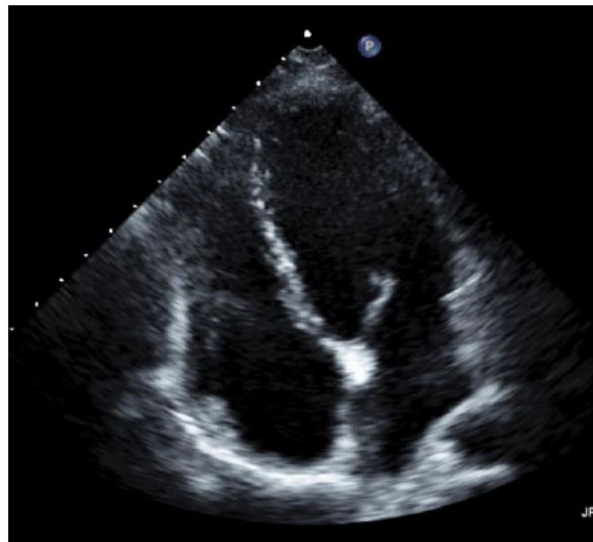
Transthoracic echocardiogram images of a normal diastolic left ventricular function.
